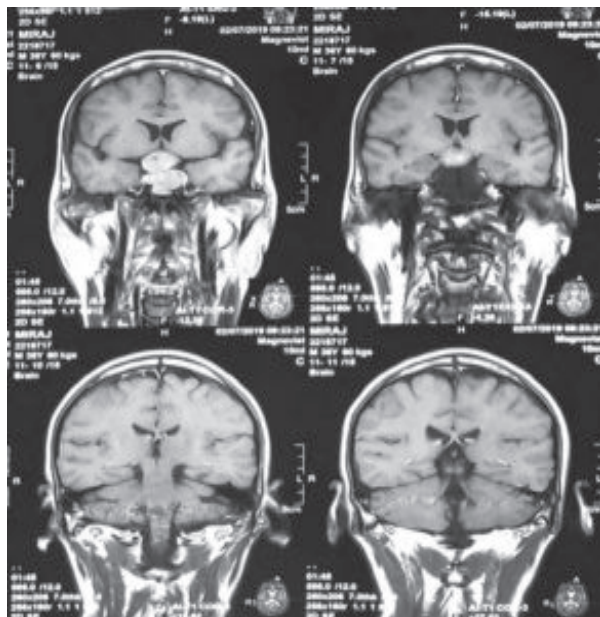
Contrast enhanced T1W coronal MR images of pituitary macroadenoma with evidence of compression on optic chiasma and third ventricle and cavernous sinus involvement
